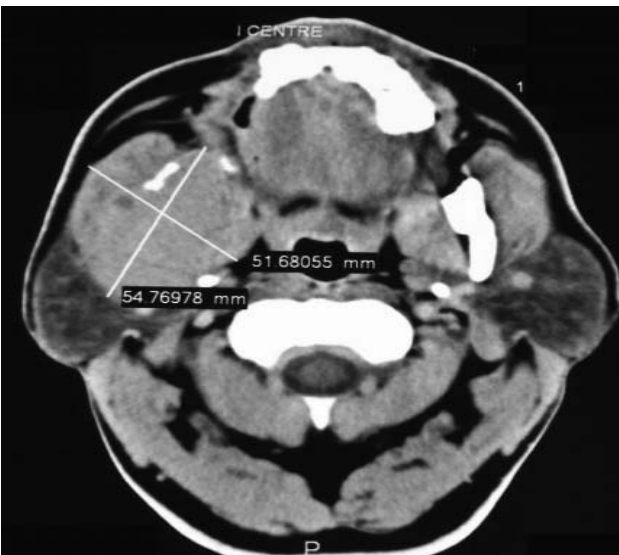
Axial CT scan showing complete erosion of ramus of right mandible also notice mass infiltrating into the ipsilateral masseter muscle.
